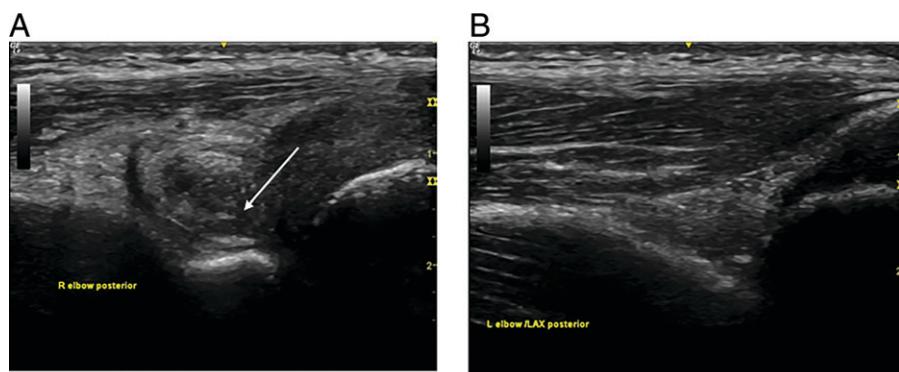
Point-of-care musculoskeletal ultrasonography used to detect an acute hemarthrosis in patients with hemophilia. A. Longitudinal posterior view of a right elbow demonstrating a heterogeneous, hyperechoic effusion (arrow) consistent with acute hemarthrosis. B. Longitudinal posterior view of the contralateral elbow with no signs of joint bleeding.
